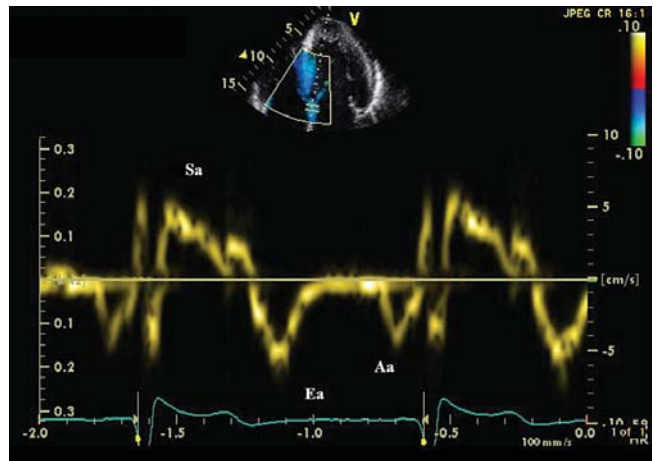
Pulse wave tissue Doppler imaging from the septal mitral annulus demonstrating the systolic Sa and diastolic Ea and Aa velocities.
